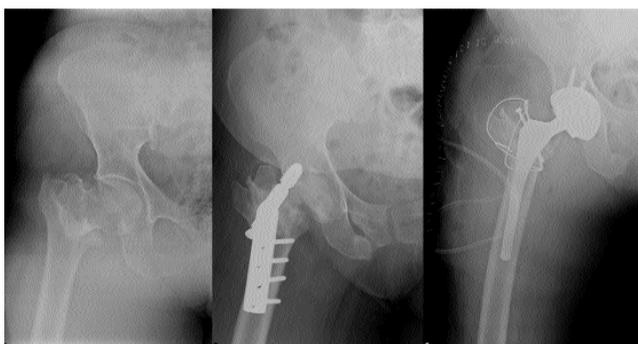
A. Plain radiograph of a 61-year-old woman showing an Evans type 4 intertrochanteric fracture of left femur. B. Another radiograph taken 12 months post-surgery shows the screw cutting through right femur. C. Appropriate alignment is seen on this radiograph obtained after total hip replacement.
